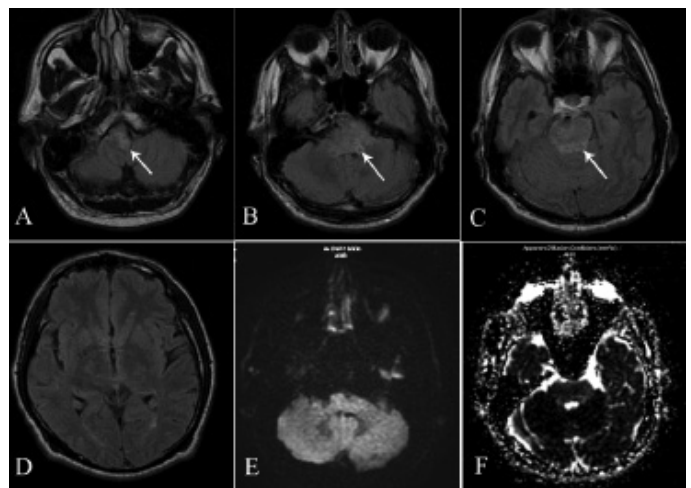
Axial FLAIR images (A, B, C, D) show a wide-spread increase in intensity in the brainstem. The parietooccipital lobe is seemingly preserved. The diffusion-weighted images (E) show a normal outlook while the increase in ADC (F) draws attention.
